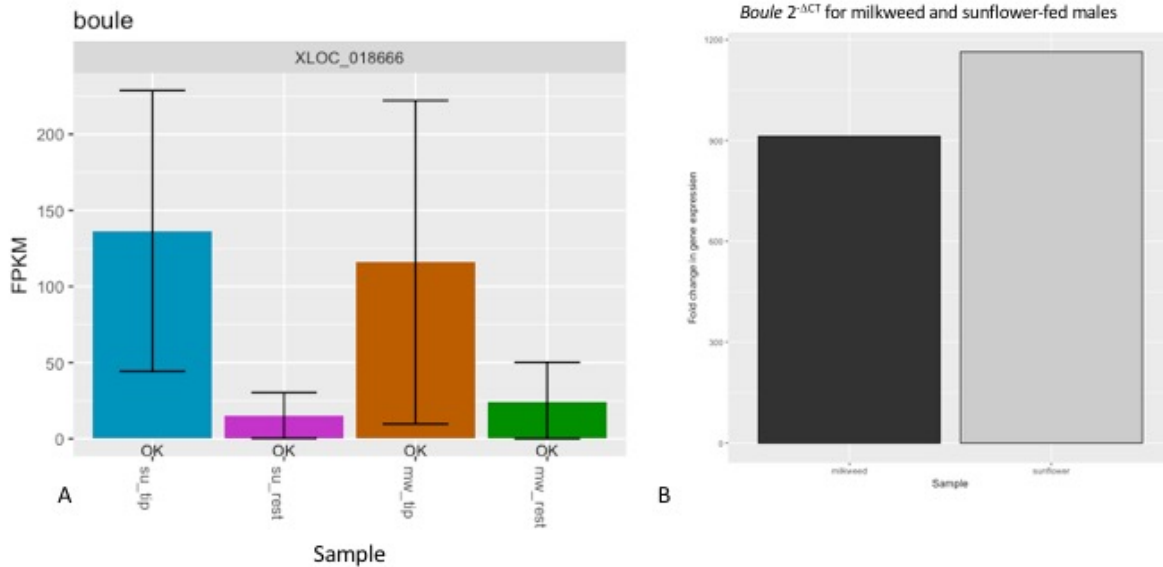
boule* is upregulated in testis distal tips. (A) Fragment per kilobase million (FPKM) counts for each sample and the (B) $2^{-\Delta CT}$ measurements for *boule*. The FPKM (A) shows the relative amount of expression per sample; error bars represent the confidence interval for each sample. There is a trend for there to be more transcripts in the sunflower distal tip than in the milkweed distal tip, as well as compared to the sunflower and milkweed proximal rest. The $2^{-\Delta CT}$ values (B) show more transcripts in sunflower-fed males than milkweed-fed males.
